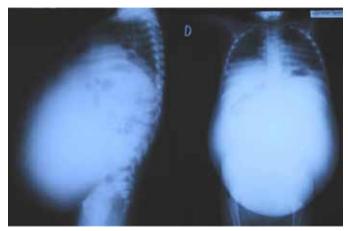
Chest and abdominal X-rays revealed an opaque homogenous mass with displacement of the intestines to posterior and upper area.
